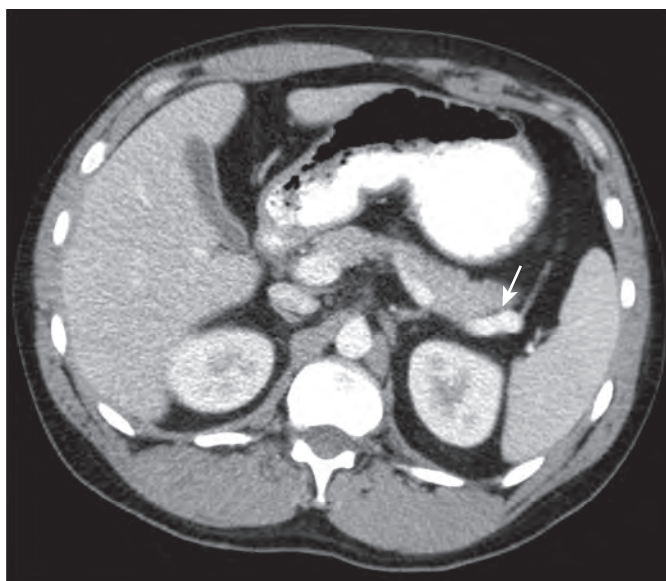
Contrast-enhanced CT shows the course of the splenic vein (arrow) posterior to the pancreas and anterior to the left kidney.
